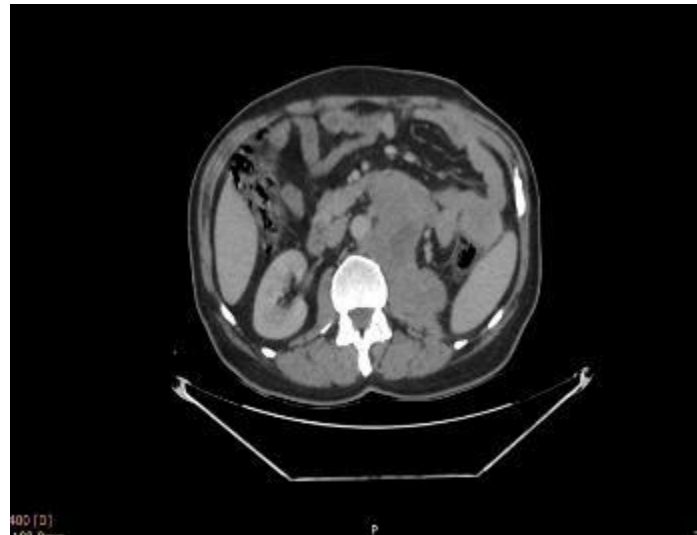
Axial contrast-enhanced CT image showing a large heterogeneous mass in the left renal fossa with areas of necrosis and invasion of the left psoas muscle
